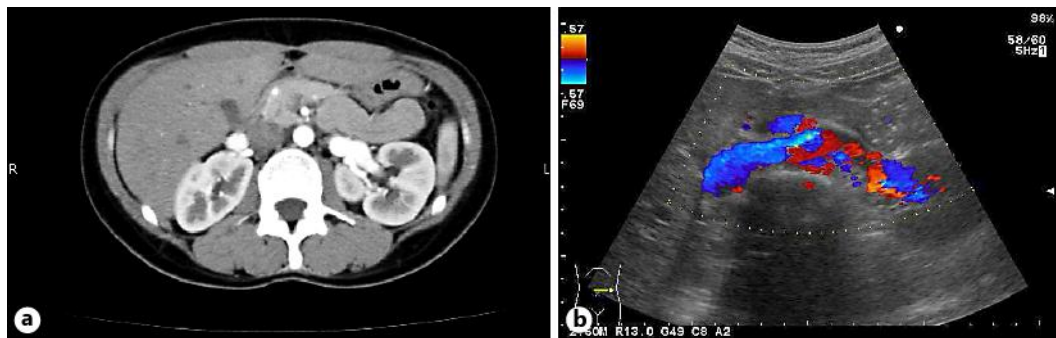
a Contrast-enhanced abdominal CT. Early filling of a dilated renal vein in the arterial phase, which is consistent with AVF. b Color-coded Doppler sonography showing AVF. Increased color saturation toward blue can be seen on the surface of the kidney.
